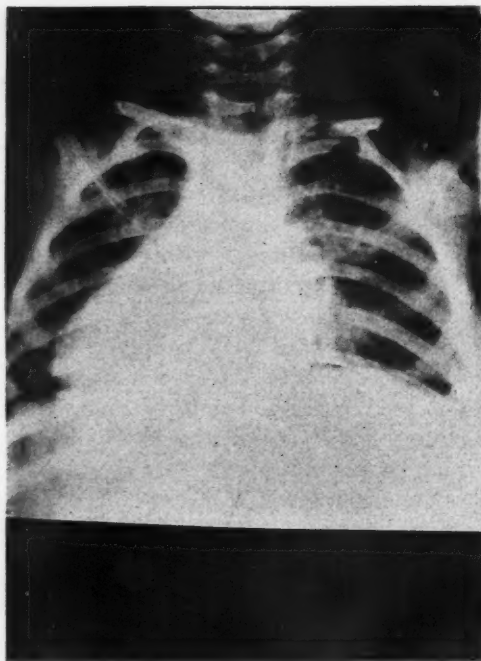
Case 1. Radiograph taken March 14, 1926. No consolidation or collapse was present at this time, but slight deviation of the trachea toward the involved side was already present.
